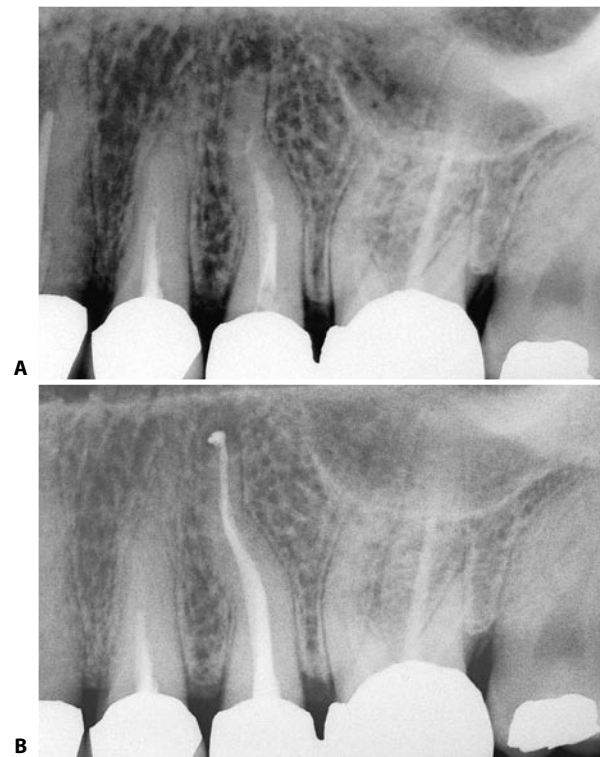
An upper left second premolar with a double bayonet curve. Note, proceeding corono-apically, the first curve directed mesially and the second directed distally. A. Preoperative radiograph. B. One year recall.
